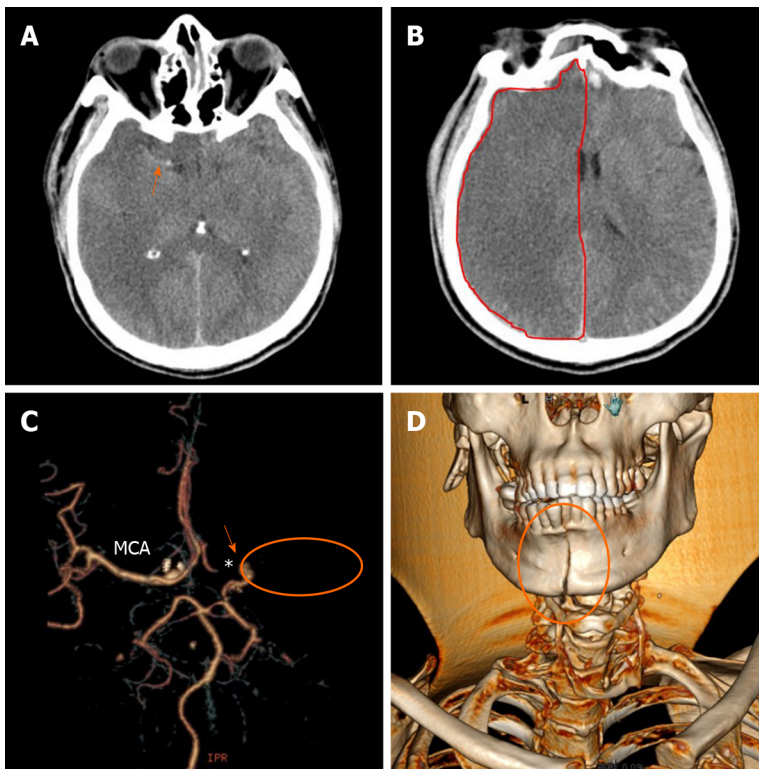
Imaging of case 2. A: Computed tomography (CT) showed a hyperdense right middle cerebral artery sign (arrow); B: CT revealed a large hypodense lesion with a mass effect in the frontotemporoparietal region (in the red line region) and a brain contusion in the frontal lobe (arrow); C: CT angiography examination revealed the anterior cerebral artery origin (asterisk) and middle cerebral artery (ellipse) occlusions suggestive of internal carotid artery dissection (arrow); D: A 3D-CT scan showed a mandibular fracture (ellipse). MCA: Middle cerebral artery.
